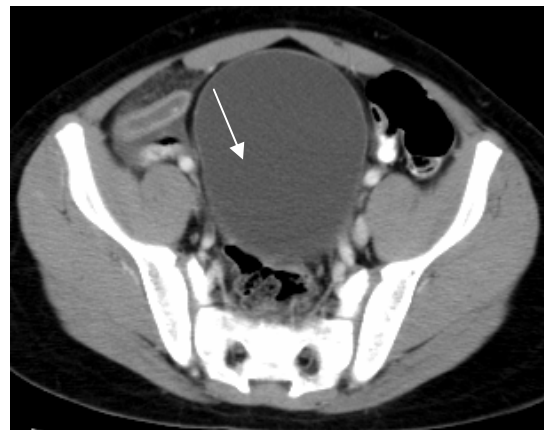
CT scan showing a fusiform, fluid-filled appendix.
